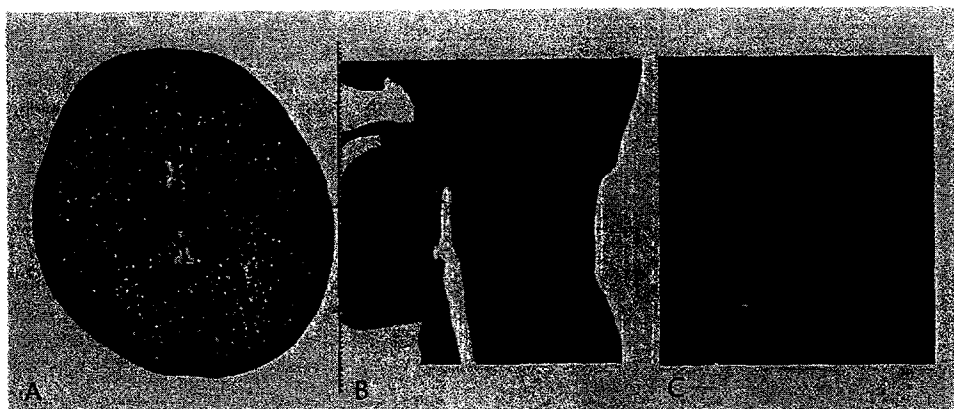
Images obtained from a 22-month-old boy with SCIWORA (caused by backward fall and parietal head impact) and hypoxic-ischemic injury and RHs. A, Axial brain CT image shows (1) bilateral cerebral low densities with decreased gray-white matter differentiation (edema) and (2) small high-density asymmetrical cerebral, extracerebral, and posterior interhemispheric hemorrhages. B, Sagittal reformatted cervical spinal computed tomographic image shows no spinal column abnormality (MRI not performed). C, Postmortem midsagittal section shows cervicomedullary disruption (circle). Diffuse hypoxic-ischemic axonal brain injury was also confirmed.
